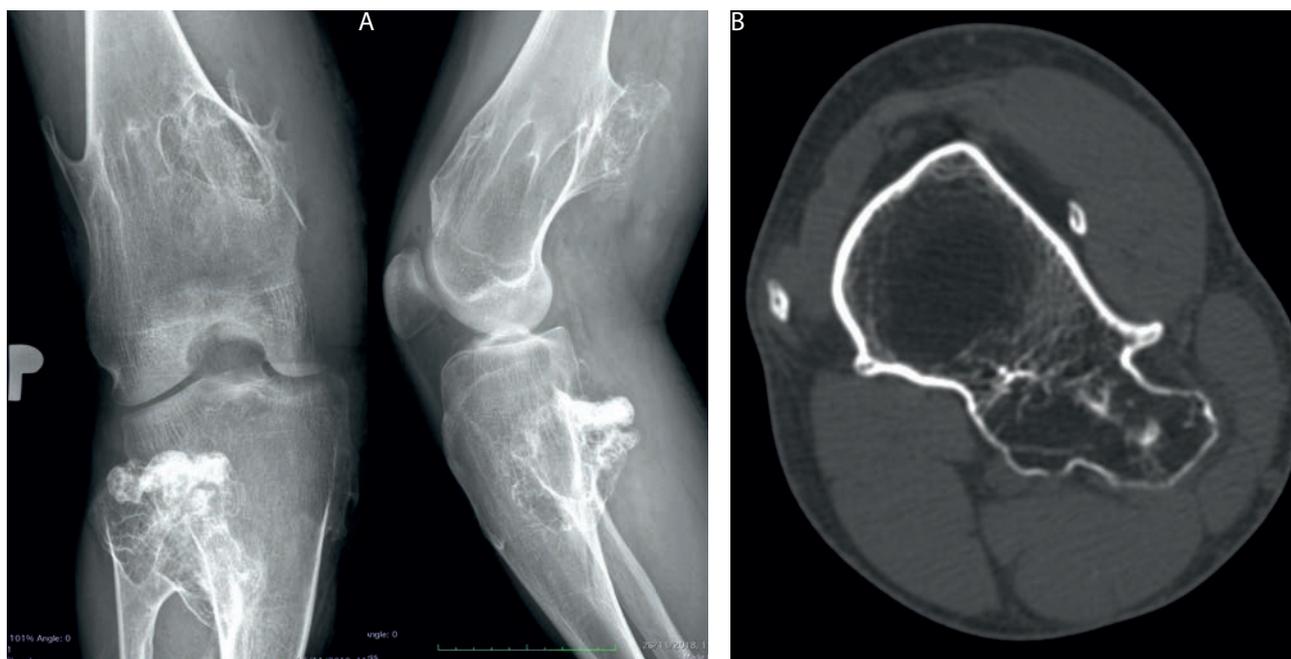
A – Patient, aged 28, multiple osteochondromas, a large osteochondroma in the tibia that grows posteriorly and to the side. B – CT reveals a dislocation of the neurovascular bundle.
